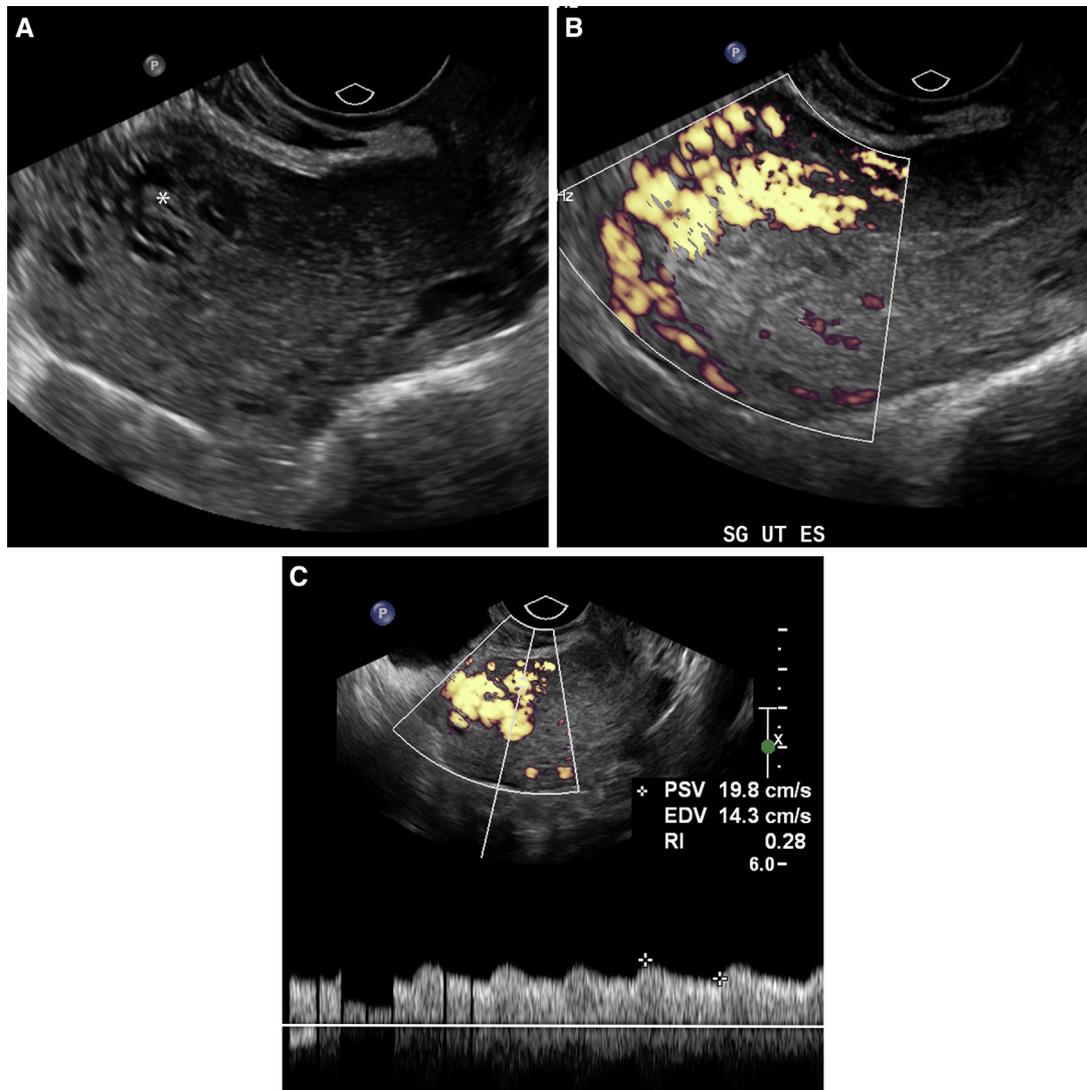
A 31-year-old woman who is 5 weeks status post D&C for anembryonic pregnancy. She had vaginal bleeding 1 week prior to presentation with a positive serum human chorionic gonadotropin (HCG) that was treated with repeat dilation and curettage and misoprostol. Her hematocrit fell from 29 to 20 in the emergency room on this admission when her serum HCG was negative. (A) Transvaginal sagittal ultrasound demonstrates heterogeneous anterior myometrium with multiple cyst-like spaces that represent abnormal vascular channels from a uterine arteriovenous fistula (asterisk). (B) Transvaginal sagittal ultrasound with power Doppler demonstrates endometrial thickness of less than 10 mm, and there is marked hypervascularity in tortuous vessels in the anterior myometrium. (C) Transvaginal ultrasound with pulsed Doppler demonstrates the peak systolic velocity is 19.8 cm/second and the resistive index (RI) is 0.28. This is a relatively slow flow uterine arteriovenous fistula and peak systolic velocities are typically higher. There were also prominent vessels in the left adnexa (not shown). She was treated with blood transfusions and recovered. EDV = end diastolic velocity; PSV = peak systolic velocity. This figure is available in colour online at <http://carjonline.org/>.
